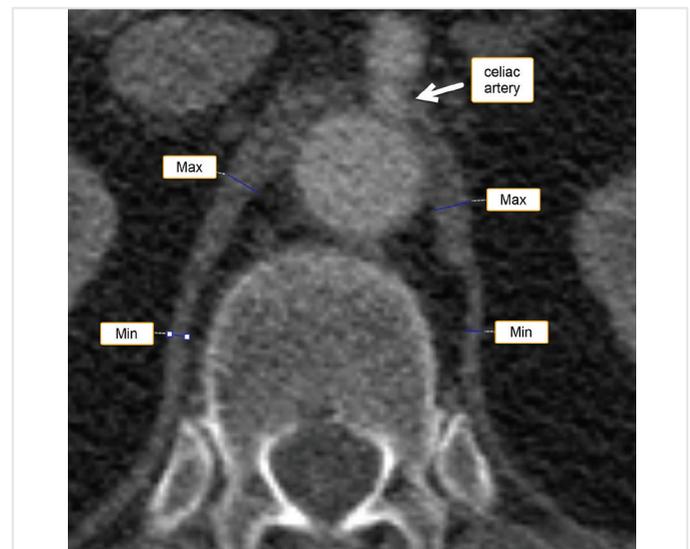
a) Axial computed tomography scan at the celiac artery origin level (arrow) shows maximum and minimum diaphragm thickness measurements
